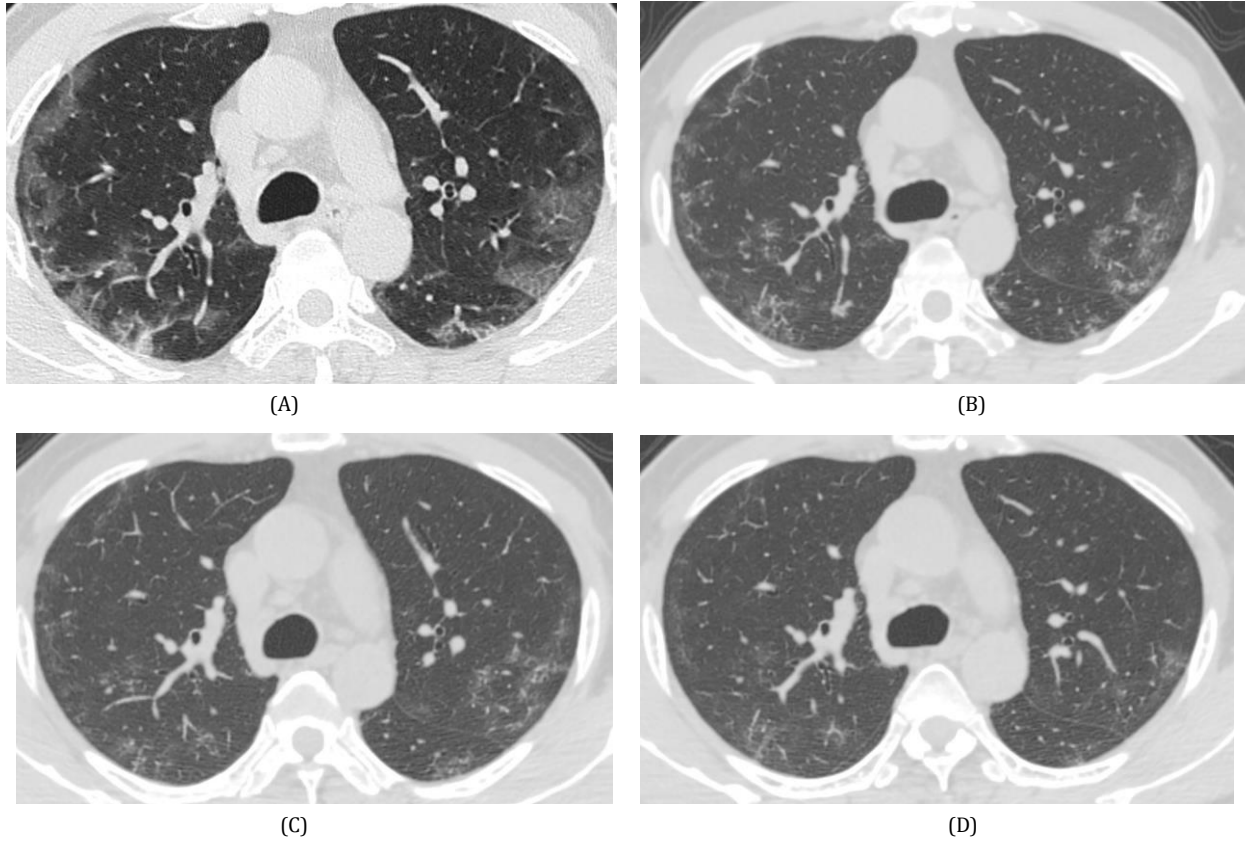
A 54-year-old male patient with COVID-19. The first computed tomography scan showed the anti-butterfly wing sign (A). From the first to third computed tomography scan, the lesions gradually decreased (B-D).
